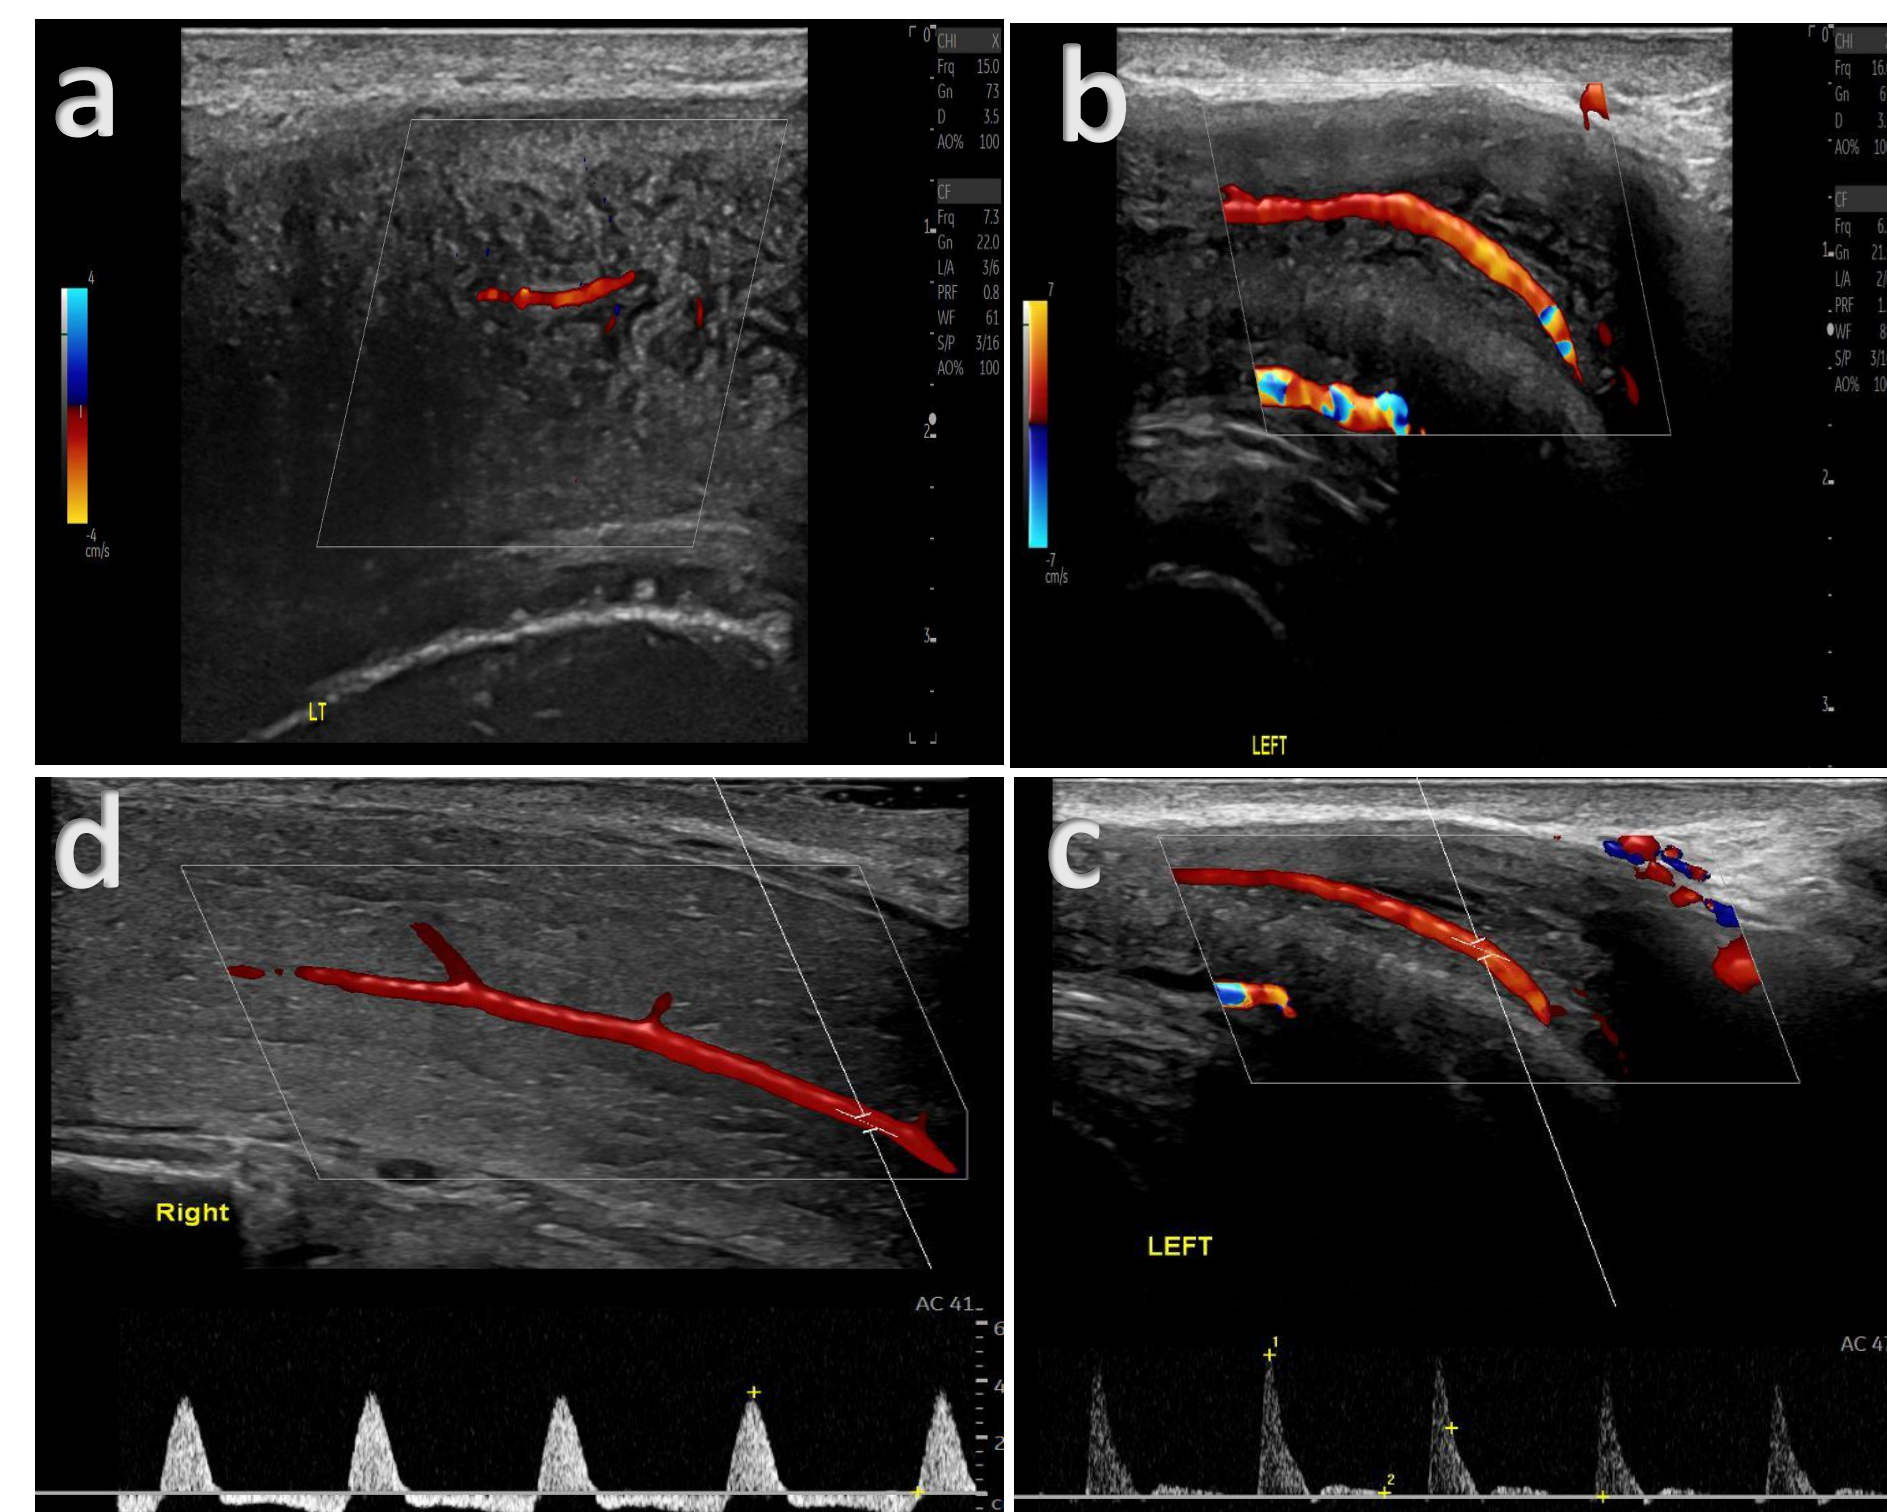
Doppler ultrasound of the penis post Caverject injection. (a) depicts the expanding sinusoids of the left CC and a short segment of the cavernosal artery. (b) CDI of the cavernosal artery and the expanding sinusoids in response to the injection. (c) Left cavernosal artery post Caverject injection - spectral Doppler - PSV 45 cm/s EDV 1.4 cm/s - Good response to Caverject. (d) Reverse diastolic flow at full erection – an expected findings in a normal penis.
